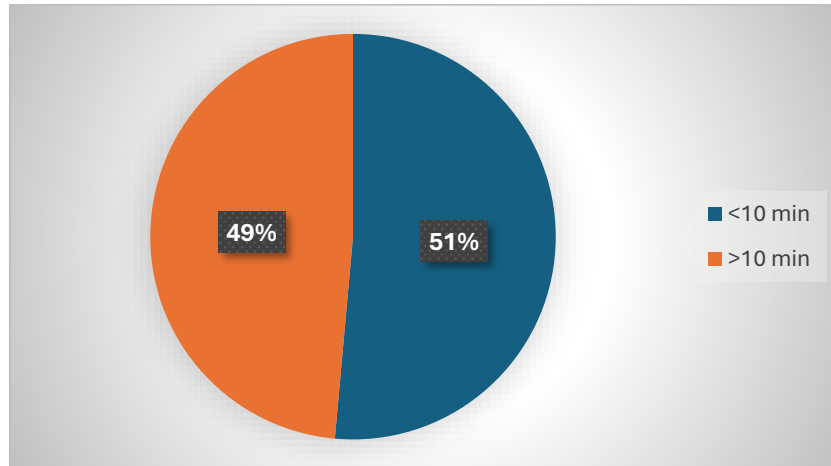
Average Waiting Time for report generation in X-ray
